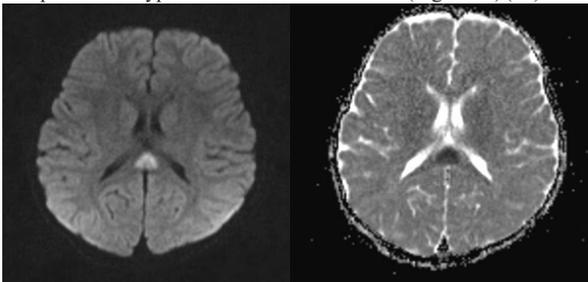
DWI shows hyperintense area in splenium of corpus callosum showing low ADC value, representing transient lesion of splenium of corpus callosum.
